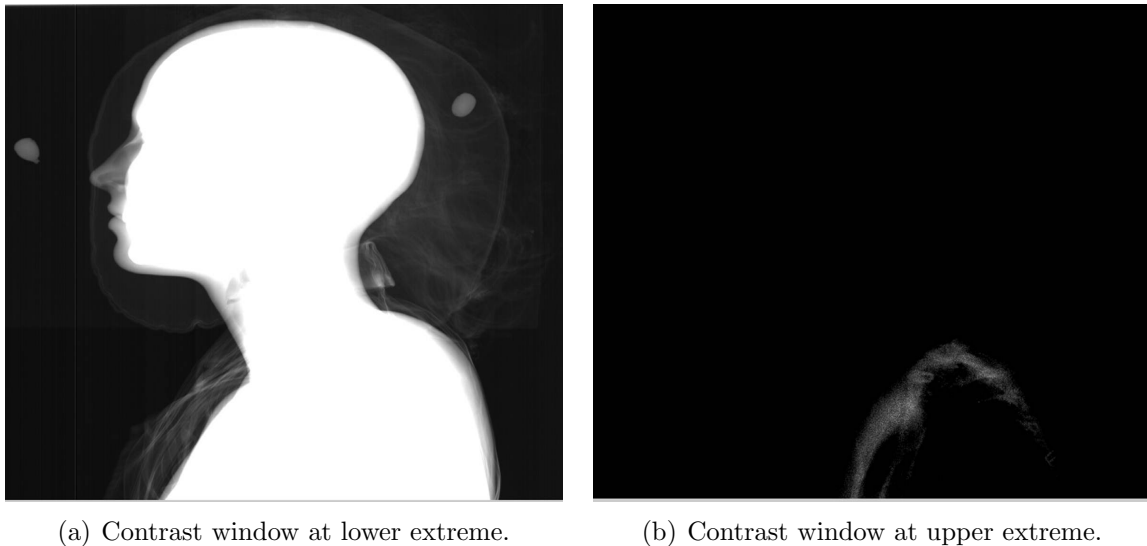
X-ray images at the contrast extremes.
